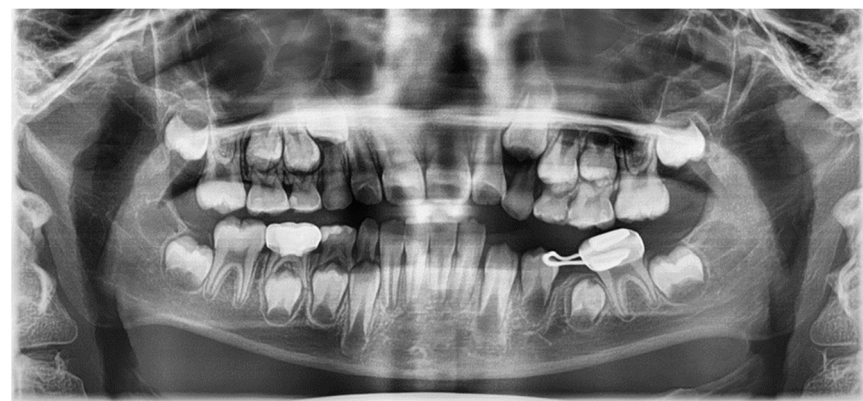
Four years after tooth extraction. Panoramic radiograph. Development of successive permanent tooth was observed (pre-eruptive phase).
